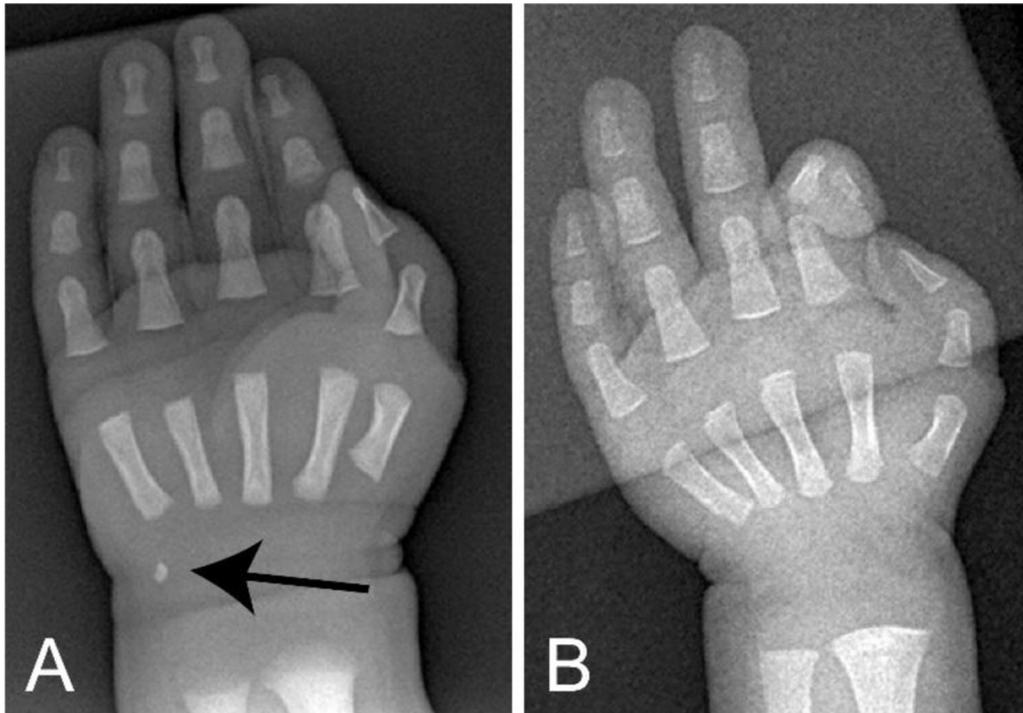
Chondrodysplasia punctata. (A) The radiograph of the infant's hand demonstrates stippling (a spot) near the proximal end of the fifth metacarpal (arrow). (B) The radiograph of an unaffected, same-aged child is shown as a reference.
